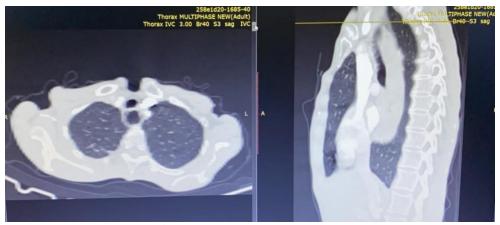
CT scan preoperatively
